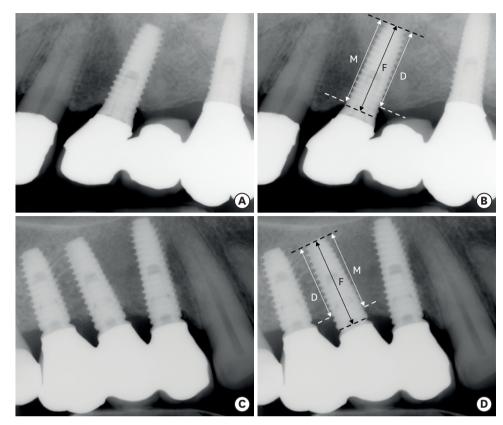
Methods of measuring marginal bone loss on radiographs. (A, B) External-type implant (#24!). (C, D) Internal-type implant (#15!).
